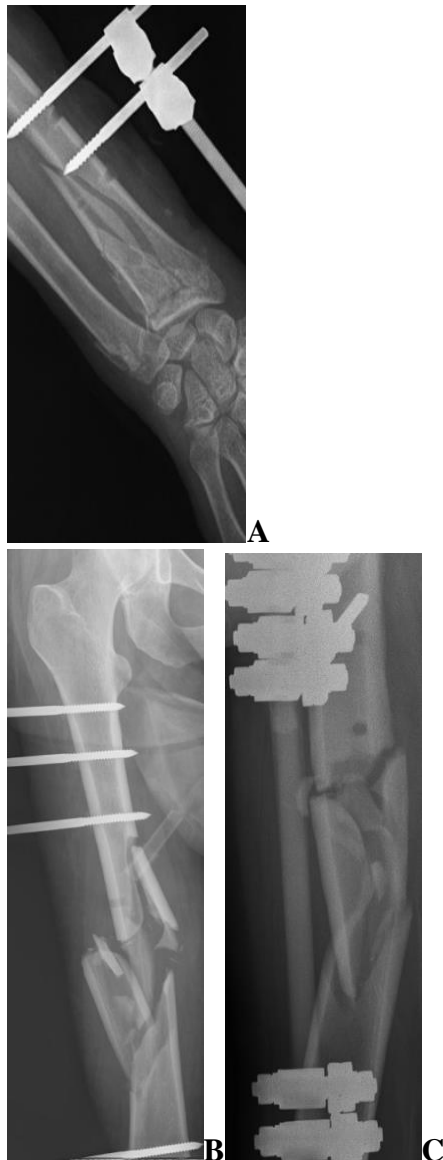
Case 2: Postoperatively imaging evaluations; A- Distal Radius Stabilization X-ray, B-femur stabilization with an external fixator X-ray
